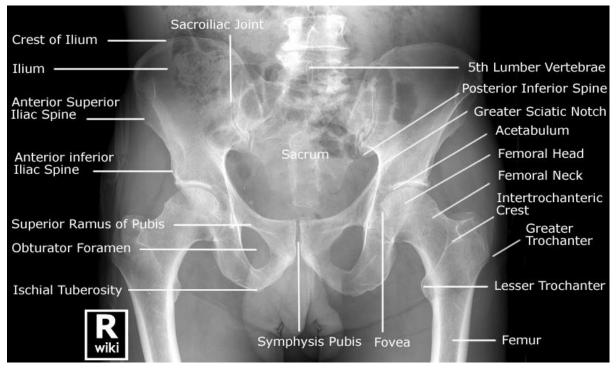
AP pelvis with bony structures labelled (Pelvis Radiographic Anatomy, n.d.)
